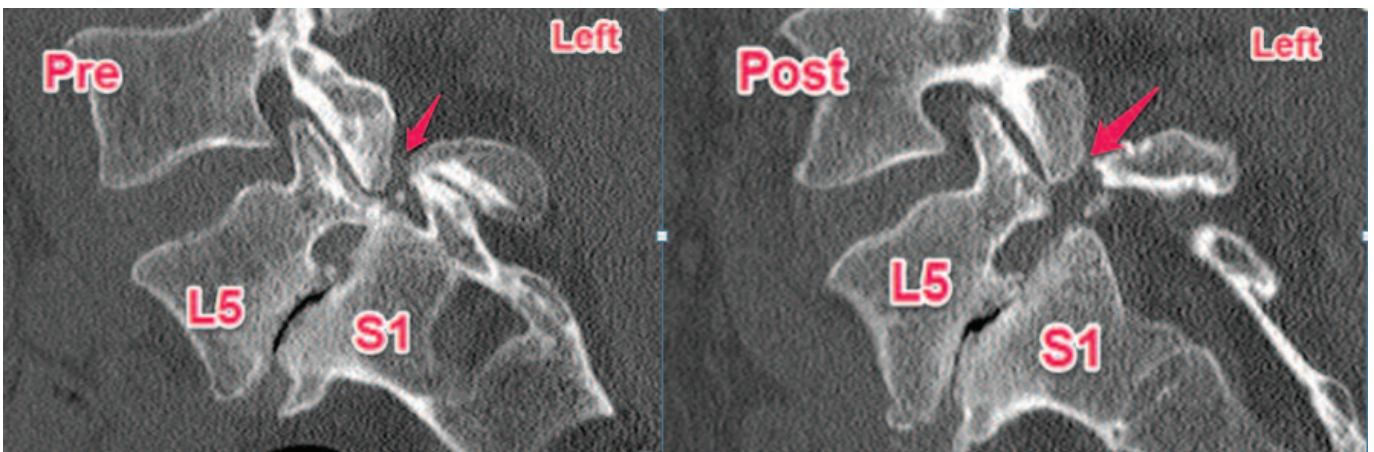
Images of the spine before and after TFELD at left L5-S1 showing that the protruding bony compression in the foramen of L5-S1 (left) was successfully removed and the foramen for the L5 nerve root was enlarged (right). Pre: preoperative CT scan; Post: postoperative CT scan. The red arrows point towards the pars fracture.
